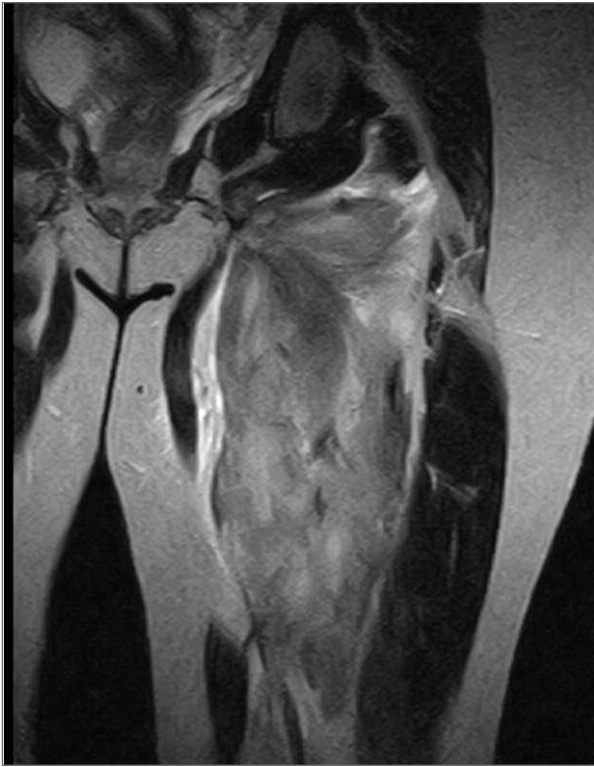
A T2 weighted magnetic resonance imaging – high signal intensity in *adductor magnus* and *adductor brevis* suggestive of local muscle inflammation
